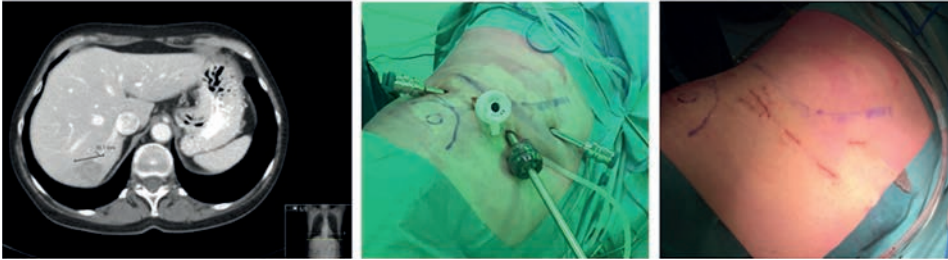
CT-scan, port placement and closed incisions of a patient who underwent a resection of a posterior segment
